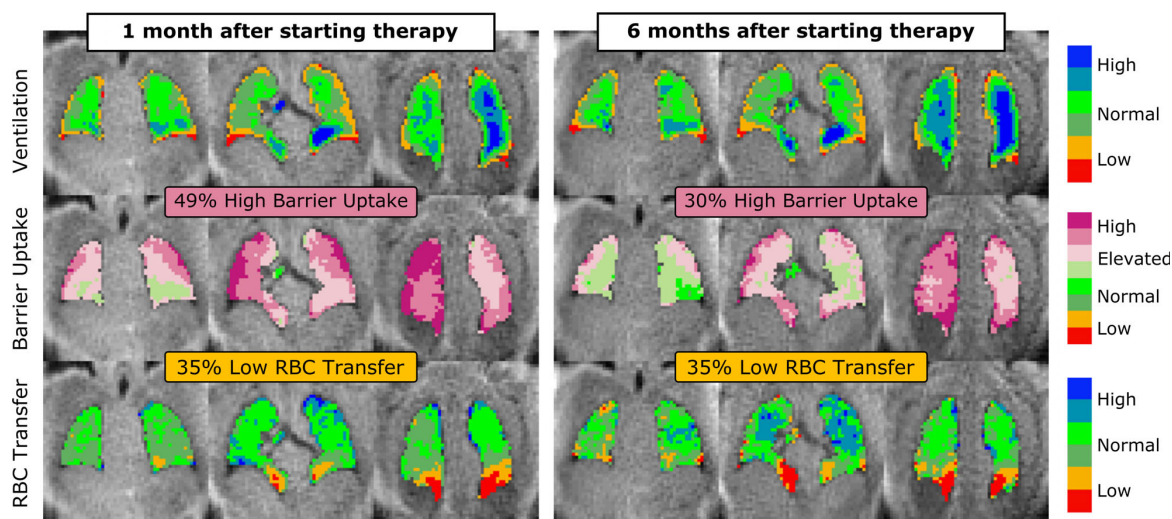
Observed improvement of ^{129}Xe gas-exchange metrics for an IPF patient on current therapy. This patient started anti-fibrotic therapy one month prior to baseline MRI and presented with 49% high barrier uptake, and focal RBC transfer defects at the lung bases resulting in 35% low RBC transfer. Upon return 5 months later, the percentage of lung exhibiting high barrier uptake had decreased to 30%, while the RBC transfer defects remained stable at 35% of lung volume. Reprinted with permission from ref. [124].
